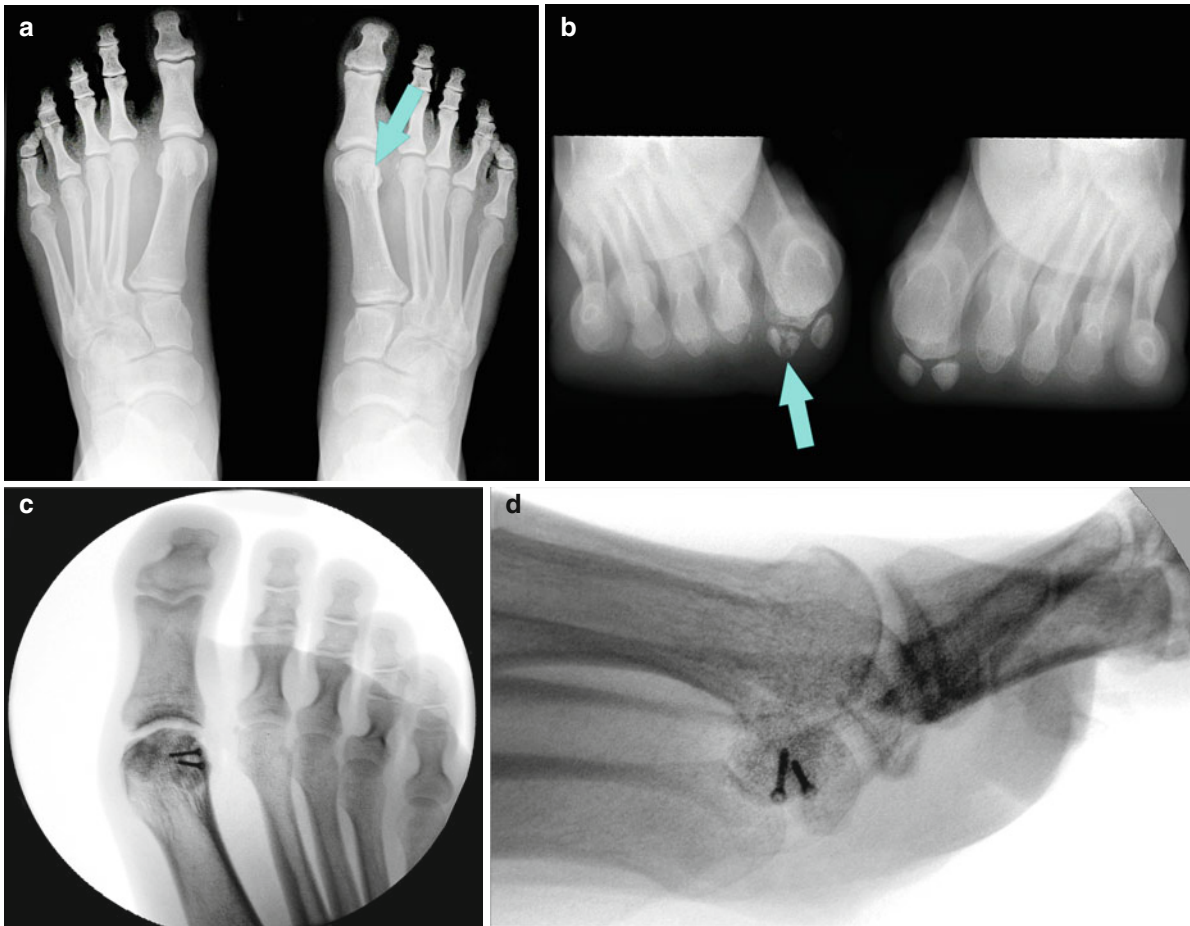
This patient suffered from a fracture of the lateral (fibular) sesamoid after a strong jump during a volleyball game. Initial X-ray analysis did not show a fracture. Because of persistent pain, follow-up X-rays were performed 4 months later, where a delayed union of the lateral sesamoid was confirmed
